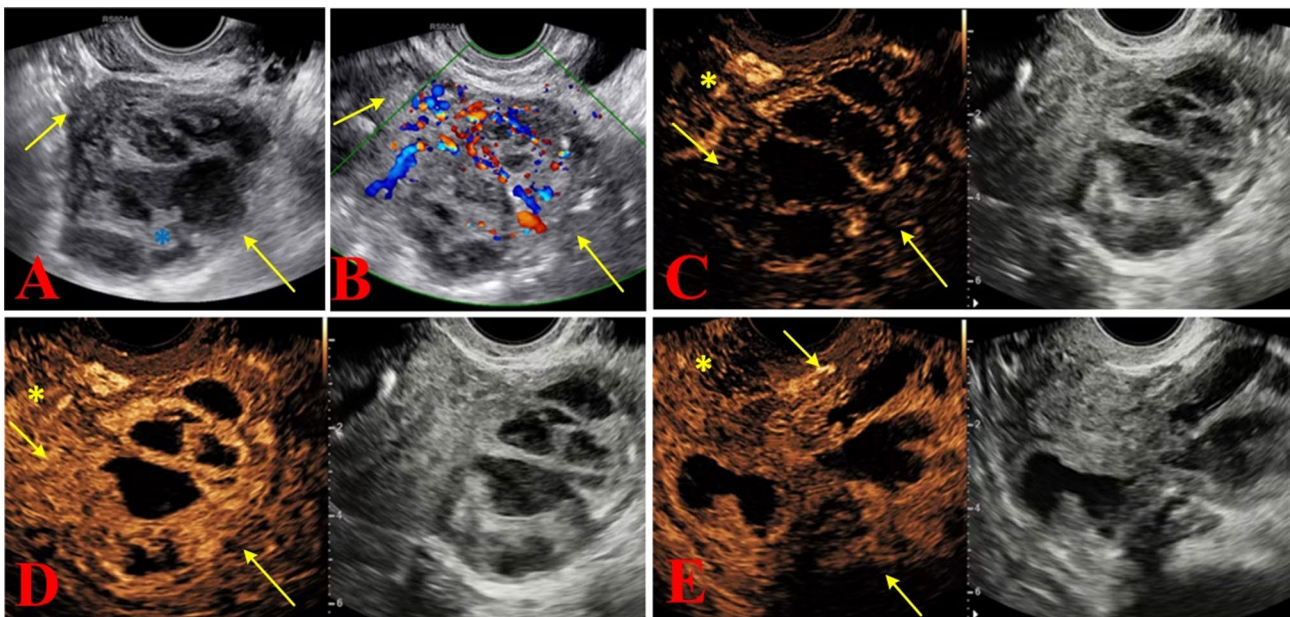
Ultrasonographic images of the inflammatory lesion located in the left adnexa of a 49-year-old female patient. The level of HE4 was 39.2 pmol/ml. (A) The ultrasonic image shows a multilocular cyst (arrows) in the left adnexal region, with solid components present (blue *). (B) Color Doppler ultrasound shows that the lesion had relatively abundant blood flow signals (color score = 4), and this lesion was classified as O-RADS US v2022 category 5. (C, D) CEUS images of the lesion show synchronous enhancement (arrows in C, score = 2) and hyperenhancement (arrows in D, score = 2) in comparison with myometrium (*). (D, E) Compared with the myometrium (*), the lesion shows a dynamic change in enhancement from hyperenhancement to hypoenhancement (score = 1). The CEUS score was 5
